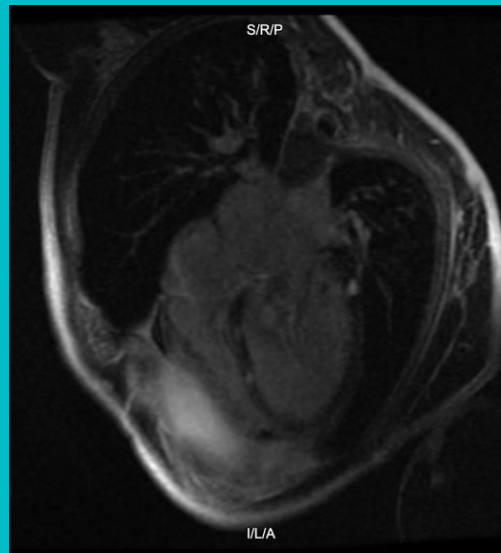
Cardiac MRI demonstrating diffuse patchy and variable late gadolinium enhancement (some subendocardial, mid-myocardial, and transmural) distribution most consistent with myocardial involvement of sarcoidosis.
